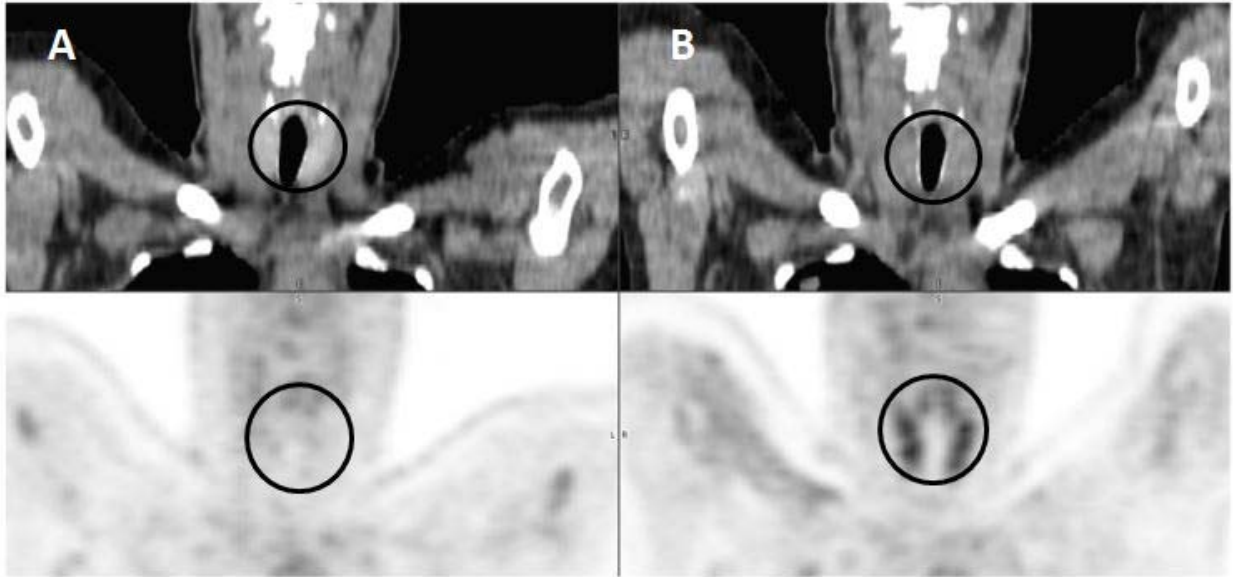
Patient with increased ¹⁸F-FDG uptake in thyroid gland during nivolumab therapy. Coronal images from the pre-therapy (A), CT (top left) and ¹⁸F-FDG PET (bottom left) displayed normal uptake in the thyroid gland with $SUV_{max} = 1.7$ (A). Coronal images from the during therapy (B), CT (top right) and ¹⁸F-FDG PET (bottom right) showed increased thyroid uptake with $SUV_{max} = 4.3$. Black circle denotes the region of the thyroid gland.
